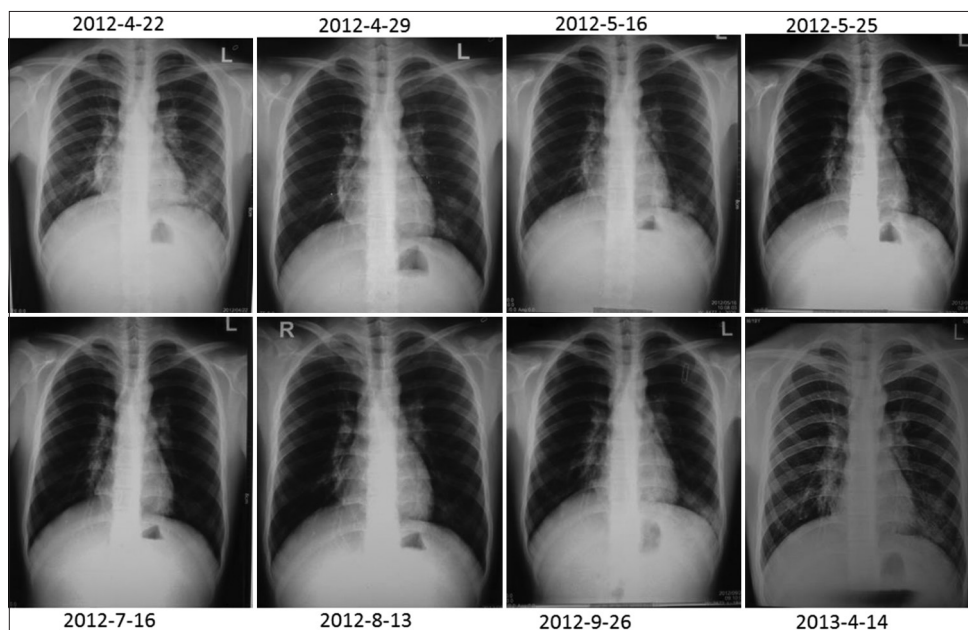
The chest X-ray of a patient with common variable immunodeficiency showed repeated pneumonia within 1 year.
